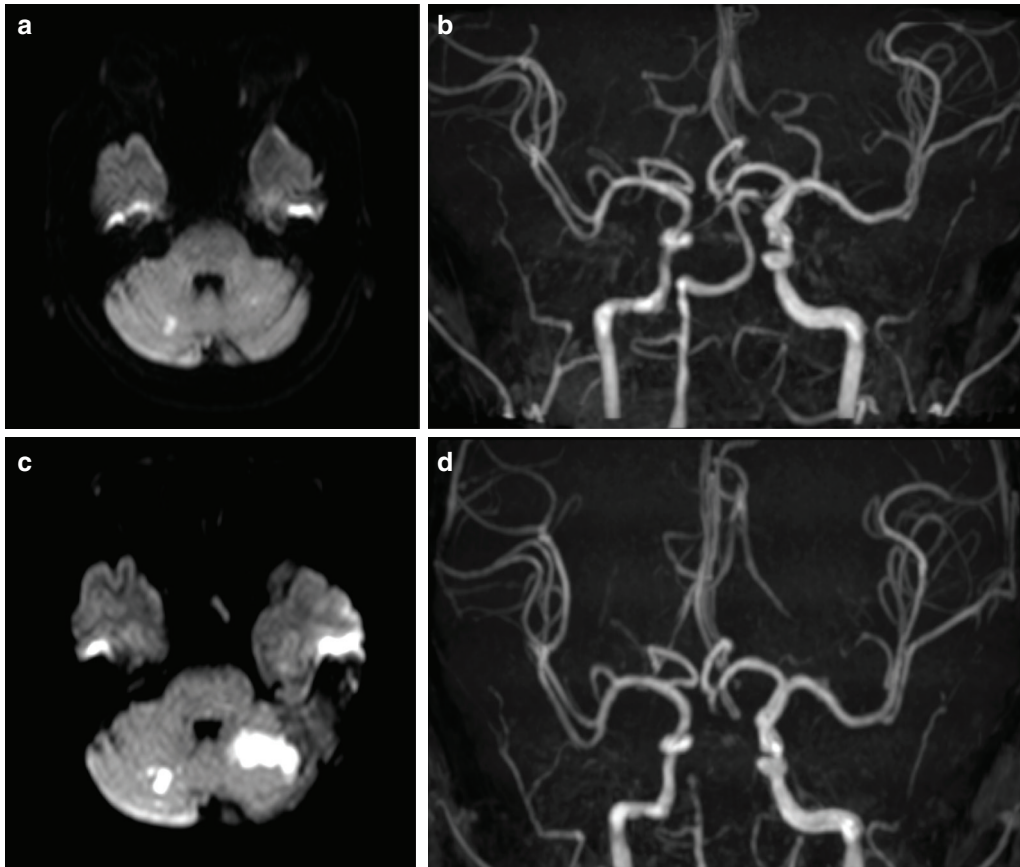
MRI and MRA, taken on admission at previous hospital, show minor infarction on the right side of the cerebellar hemisphere and intact BA (a and b). MRI and MRA, taken on admission to our hospital, show additional infarction on the other side of the cerebellar hemisphere and BA occlusion (c and d). BA: basilar artery; MRA: magnetic resonance angiography; MRI: magnetic resonance imaging
